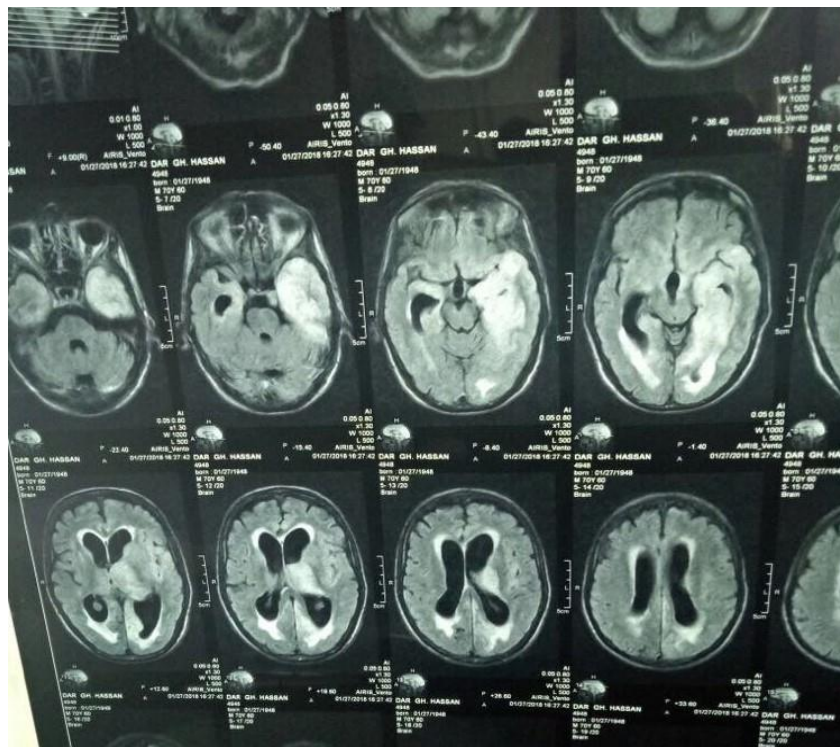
Showing repeat FLAIR image reveal hyper intensities involving the medial temporal lobe, insular cortex and left thalamus with mild mass effect. Ischemic changes are seen bilaterally in periventricular white matter.
